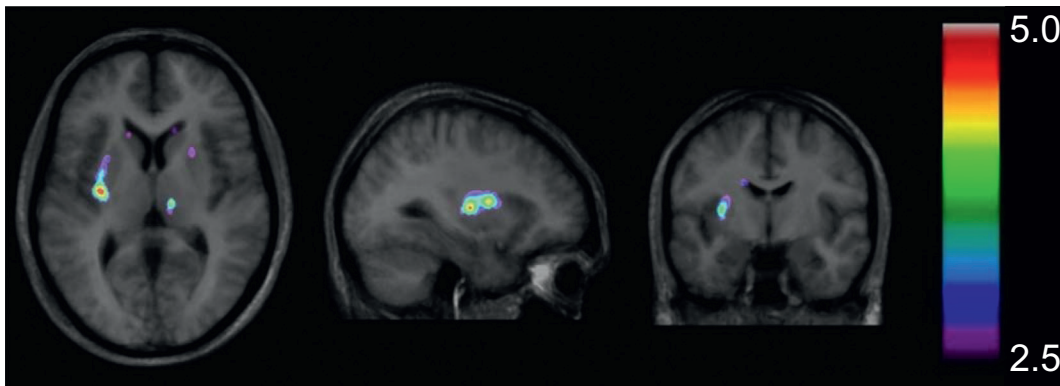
FIGURE BOX 6.4 The results of PET studies are statistical maps that show the estimated distribution of the radioactive tracer across the brain. Here, the tracer was [^{11}C] raclopride, a dopamine receptor ligand. Positive statistical values (color map shown at right) indicate increased concentrations of that ligand, which in turn indicate decreases in dopamine transmission. Note that PET images are often displayed on high-resolution structural MRI images to facilitate identification of the regions of interest. However, the PET data themselves are of much lower spatial resolution, often about a centimeter or so. *Adapted from Hakyemez et al. (2008) with permission.*
